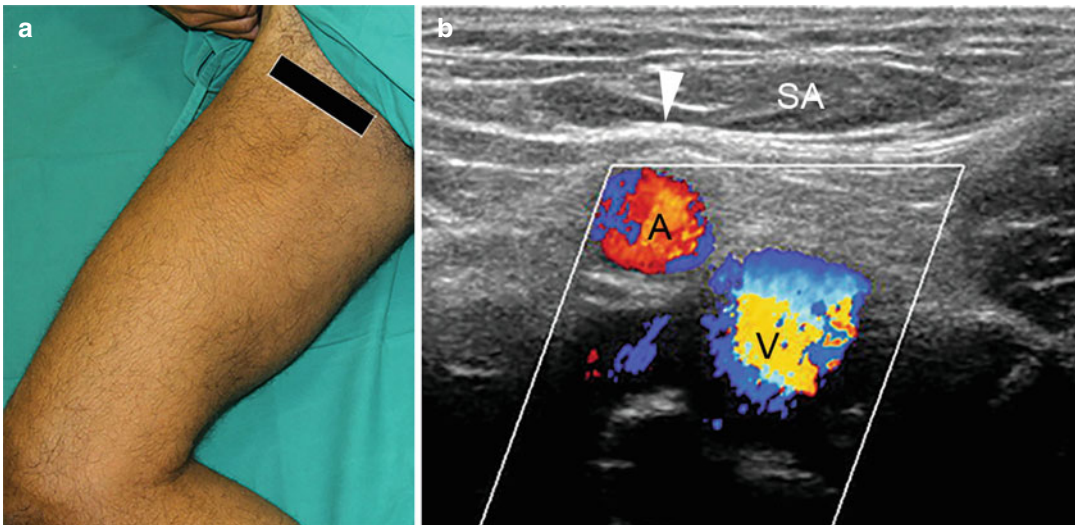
(a) US probe position on the crural region at the apex of the femoral triangle. (b) color Doppler axial scan. The deep fascia (*arrowhead*) of sartorius muscle
